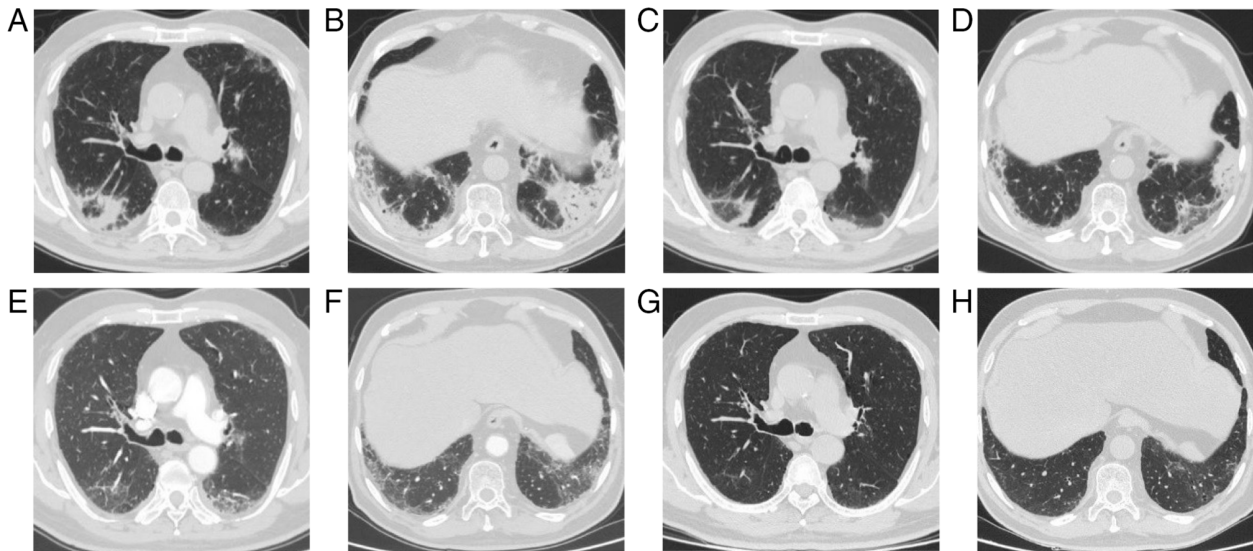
Radiological response of checkpoint inhibitor pneumonitis following tocilizumab treatment. (A) CT image at the intermediate bronchus level showing pneumonitis relapse (December 2020), which was more serious than when it first occurred. (B) CT image at the bilateral lower lung level from the same date (December 2020) also showing the relapsed pneumonitis. (C) After one cycle of tocilizumab (January 2021), the CT image at the intermediate bronchus level showed notable improvement. (D) The corresponding CT image at the bilateral lower lung level after one cycle (January 2021) also demonstrated improvement. (E) Following two cycles of tocilizumab (March 2021), further regression of pneumonitis was observed at the intermediate bronchus level. (F) The CT image at the bilateral lower lung level after two cycles (March 2021) showed continued resolution. (G) After four cycles of tocilizumab (May 2021), complete resolution of pneumonitis was achieved at the intermediate bronchus level. (H) The CT image at the bilateral lower lung level after four cycles (May 2021) confirmed complete resolution. CT, computed tomography.
